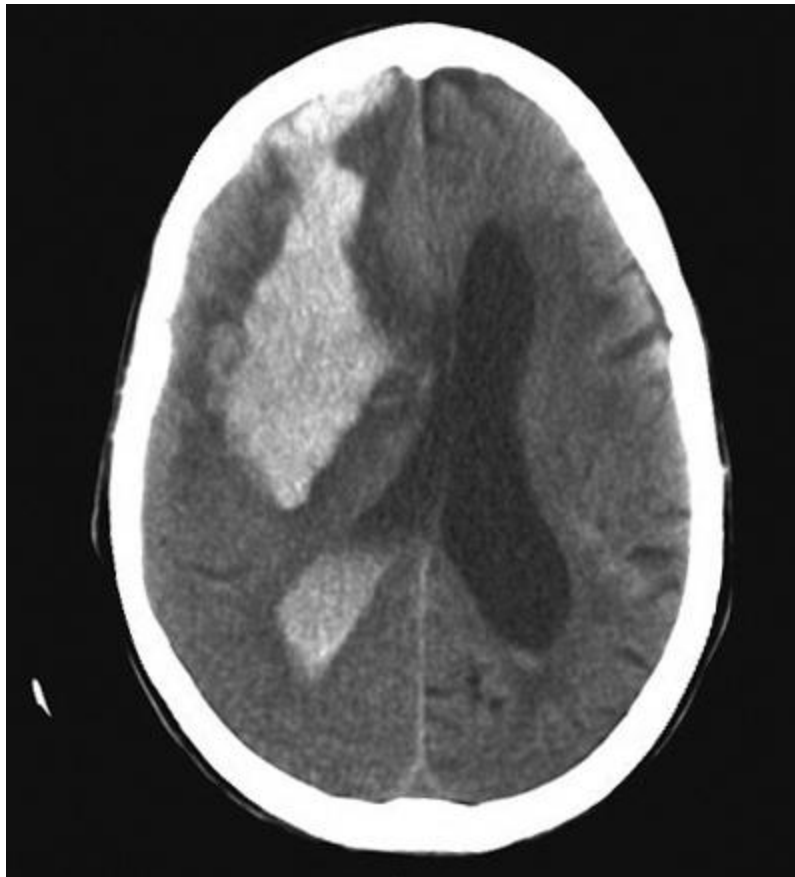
CT image of the simple skull of an 82-year-old patient that came to the imagenology ward of Juan Bruno Zayas Alfonso Hospital, with neurologic focalization signs related to full down, it showing a recent hemorrhagic focus of 82 right front parietal HU, measuring 93.6mm x 41.4mm that floods the ventricular system, note the blood content in both occipital horns a predominance of the right side, associated with perilesional edema that clears the cerebral sulci at that level, collapsing the right frontal horn and compressing the body of the right lateral ventricle, which displaces the midline to 8 mm to the left.
